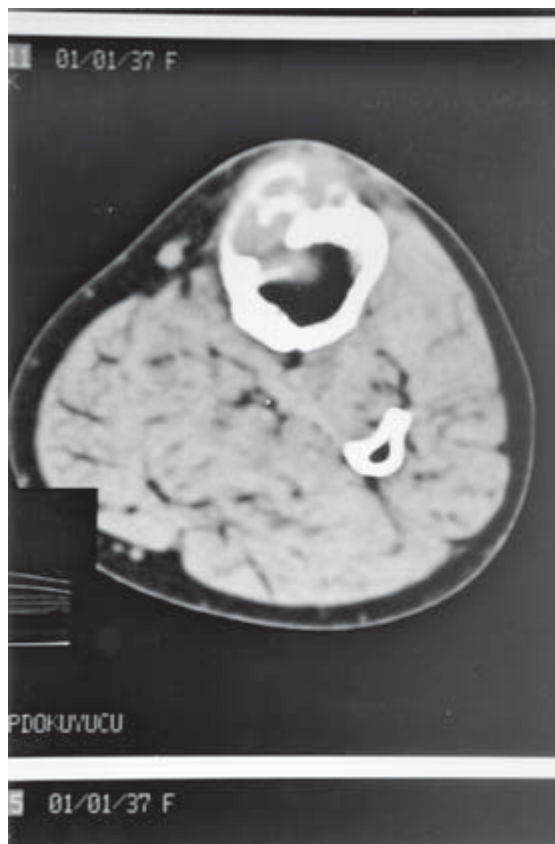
Computed tomography is demonstrated an eccentric medullar mass with cortical destruction involving soft tissue.
